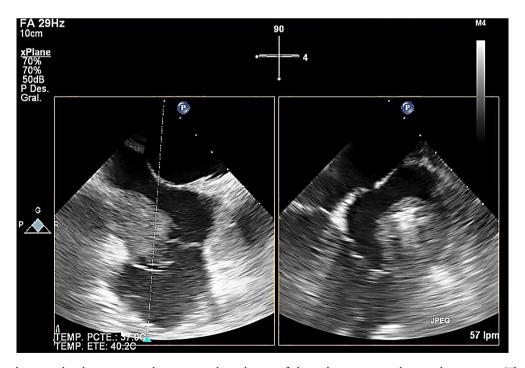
Simultaneous bi-plane imaging by transesophageal echo showing a large sessile heterogeneous mass $(3.9 \times 2.8 \text{ cm})$ attached to the lateral and inferior wall
